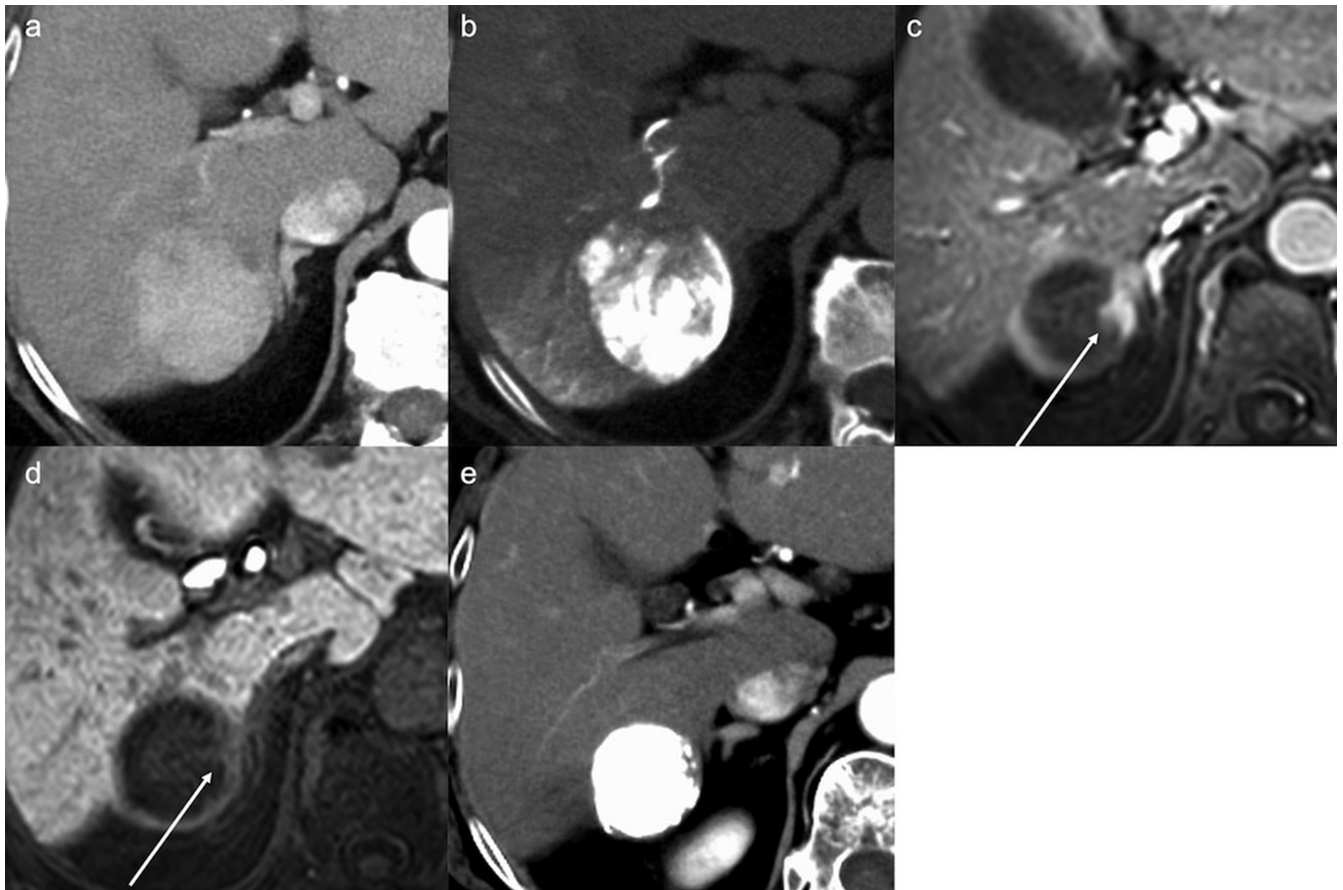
A residual lesion of a hepatocellular carcinoma after TACE with lipiodol in a 71-year-old female with hepatitis B virus-related cirrhosis. A pre-treatment CT image obtained during the arterial phase showed a hyperenhanced lesion in the segment VII (a). After lipiodol TACE, the unenhanced CT image showed the lesion presenting with heterogeneous lipiodol retention (b). Two months after the treatment, gadoxetic acid-enhanced MRI showed the viable lesion (consistent with partial response according to mRECIST) (c and d, arrow), unaffected by lipiodol, while the arterial phase hyperenhancement is difficult to detect in CT because of the beam hardening artifact (e). mRECIST, modified response evaluation criteria in solid tumors; TACE, transcatheter arterial chemoembolization.
